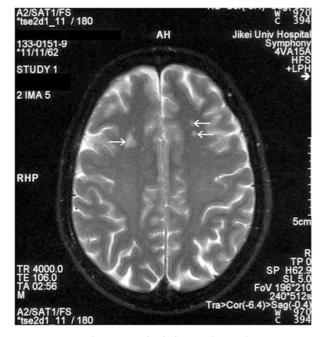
MRI showing multiple lesions (arrows).
